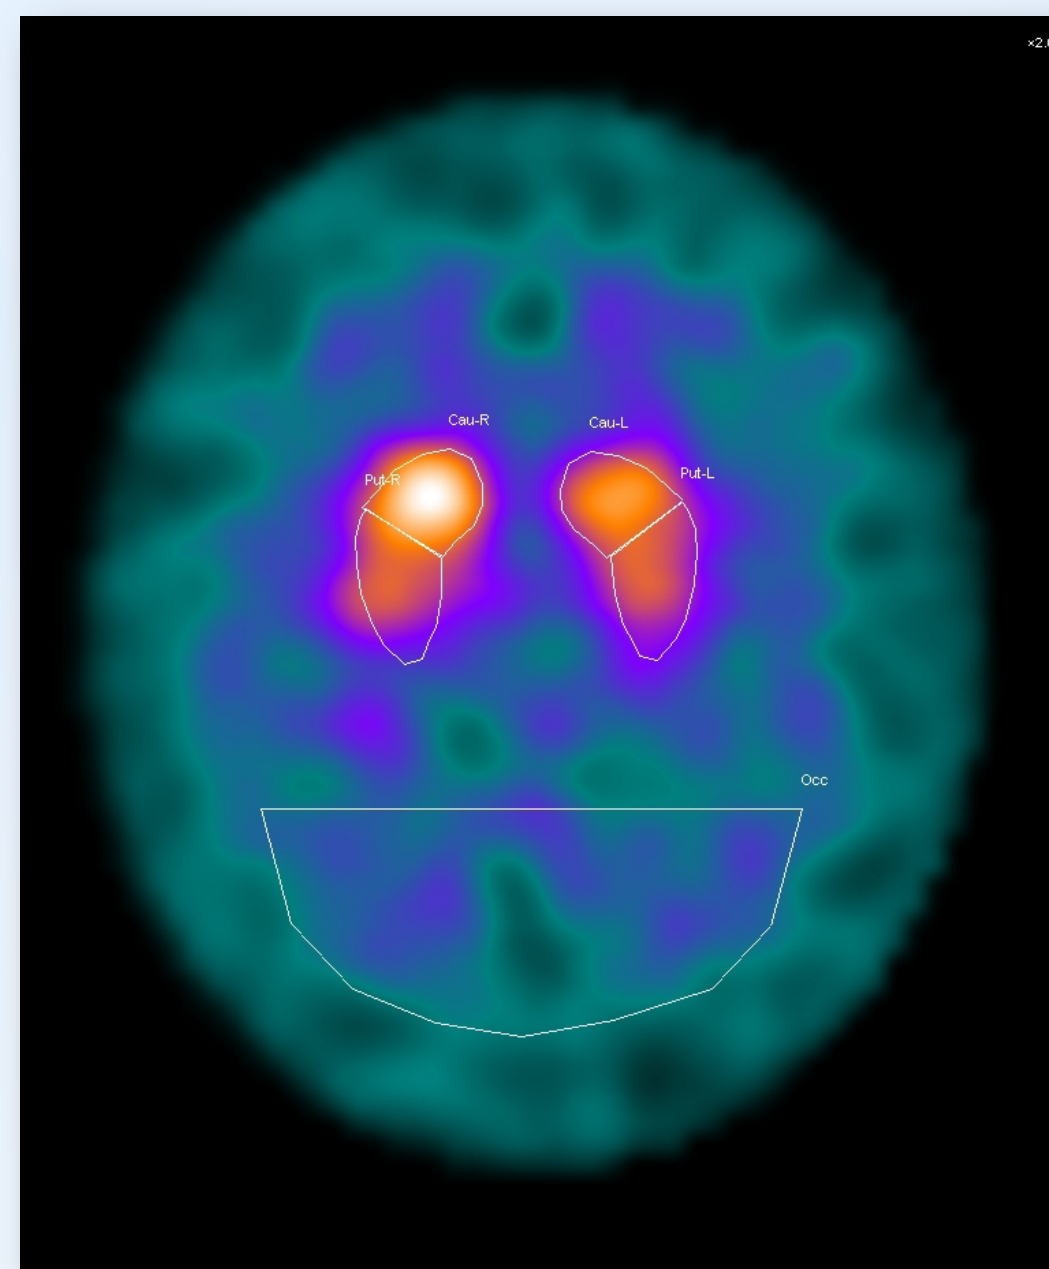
Regions of Interest (ROI) in the ¹²³I-FP-CIT SPECT
